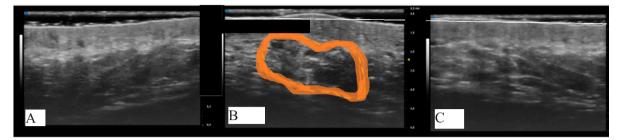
ultra-high-frequency ultrasound (UHFUS) prior to the injection of hyaluronic acid (HA) filler. Following the injection. Subsequently, UHFUS was performed again 6 months after the injection to evaluate any changes.
